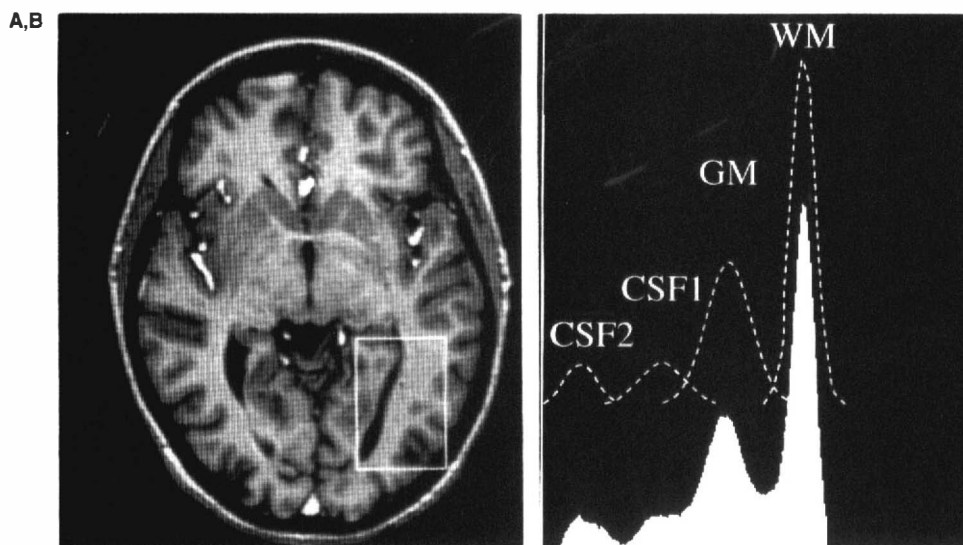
In vivo* brain tissue segmentation into gray matter, white matter, and cerebrospinal fluid compartments using MRI. (A) Transaxial MRI brain image. The region of interest in the temporoparietal area was used for the histogram shown in Fig. 7B. (B) A histogram of the posterior temporoparietal area, showing the number of MRI pixels with a given signal intensity (white area). Four peaks can be identified, corresponding to white matter (WM), gray matter (GM), cerebrospinal fluid between gray matter convolutions (CSF_1), and ventricular cerebrospinal fluid (CSF_2). Four normal distributions were fitted to the data (dotted line). The intersection of two adjacent fitted normal distributions was taken to segment the corresponding two compartments.
